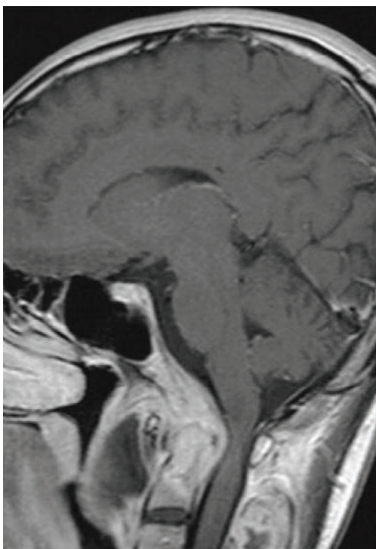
Contrast MRI retropharyngeal abscess with C2 involvement in Tuberculosis
